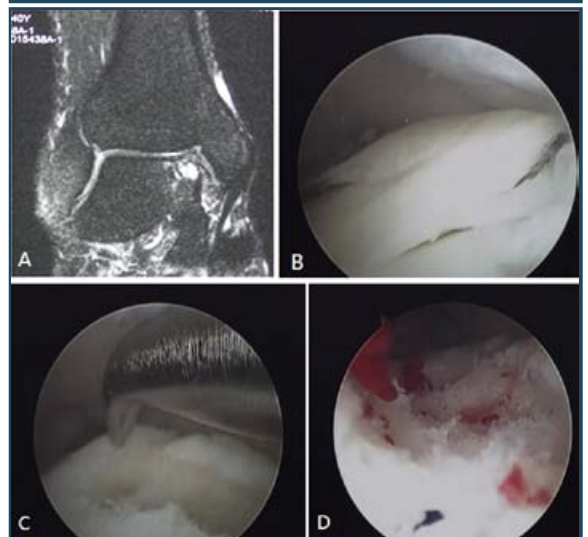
A: MRI showing increase in signal at the medial talar dome (OLT) in T2 weighted image. B: Arthroscopic view demonstrating loose cartilage flap of the OLT. C: Microfracture of the lesion after removal of the loose cartilage flap. D: Bleeding from the microfracture sites.
